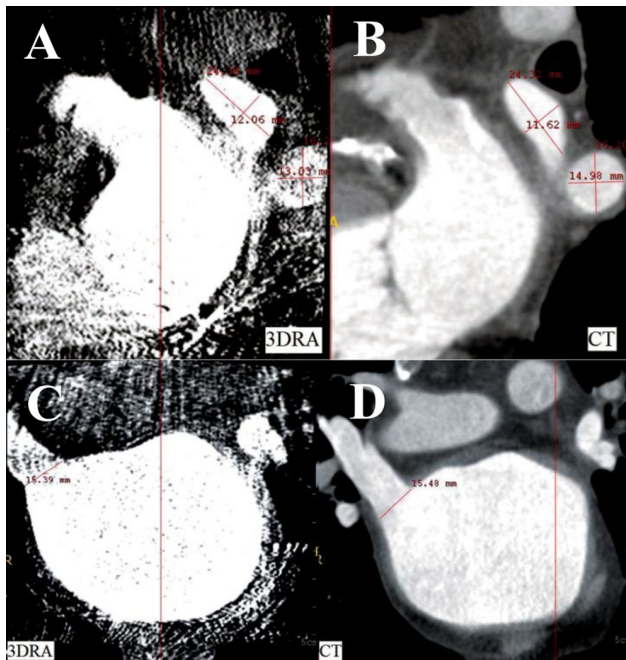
Comparison of the 3DRA of the left atrium (A,C) and CT of the left atrium (B,D) from one patient. A,B - lateral view, C,D - anteroposterior view
